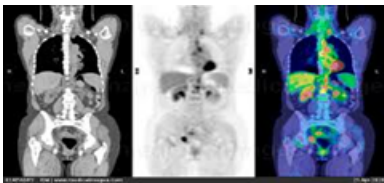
CT ALONE, PET SCAN ALONE AND PET-CT FUSION IMAGE
